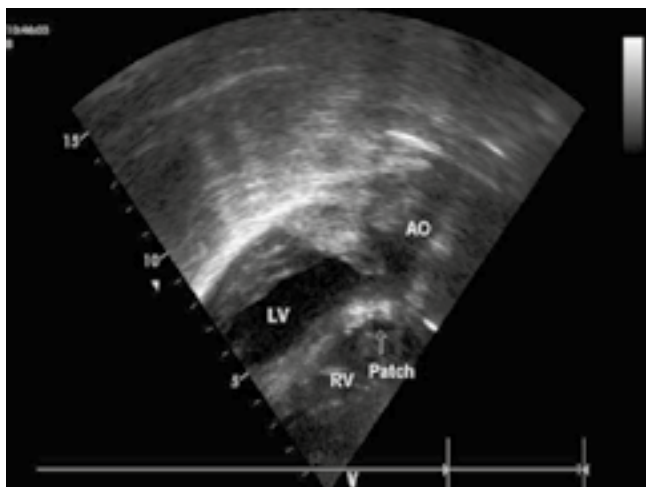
Post-surgical repair echocardiography showing Dacron patch in place
